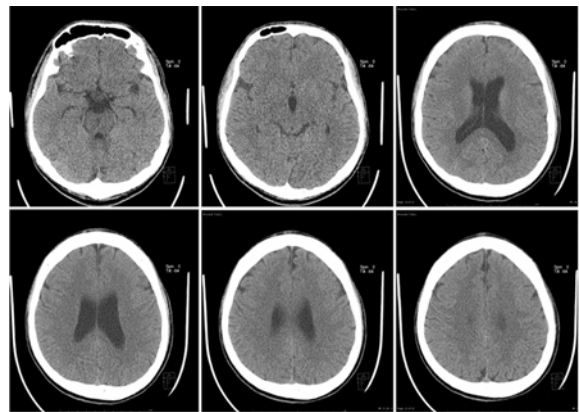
Immediate non-contrast CT of the brain after the operation showing unremarkable finding.
